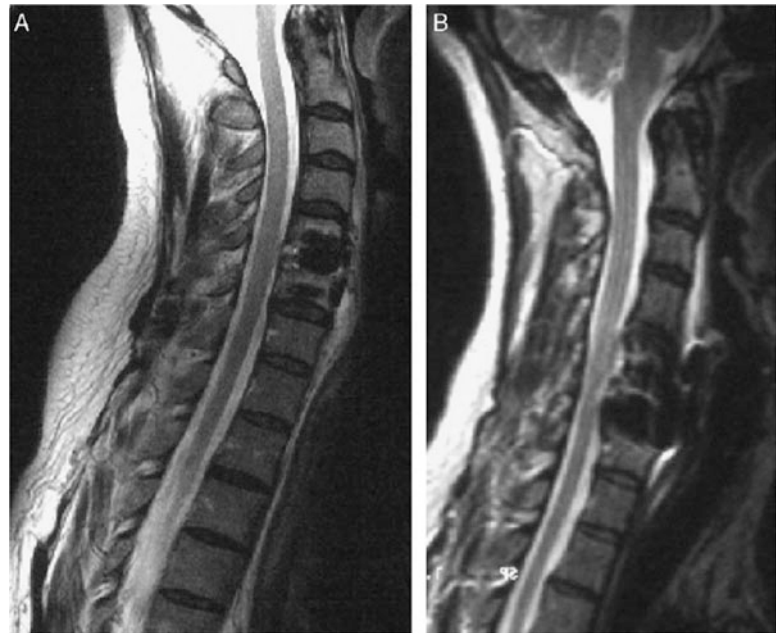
T2-weighted magnetic resonance imaging of cervical spine showing early postoperative changes after the implantation of bioresorbable plate (a) and after implantation of titanium plate (b). Notice the obvious imaging artifacts in (b) compared with (a) (Nabhan et al. 2009)
